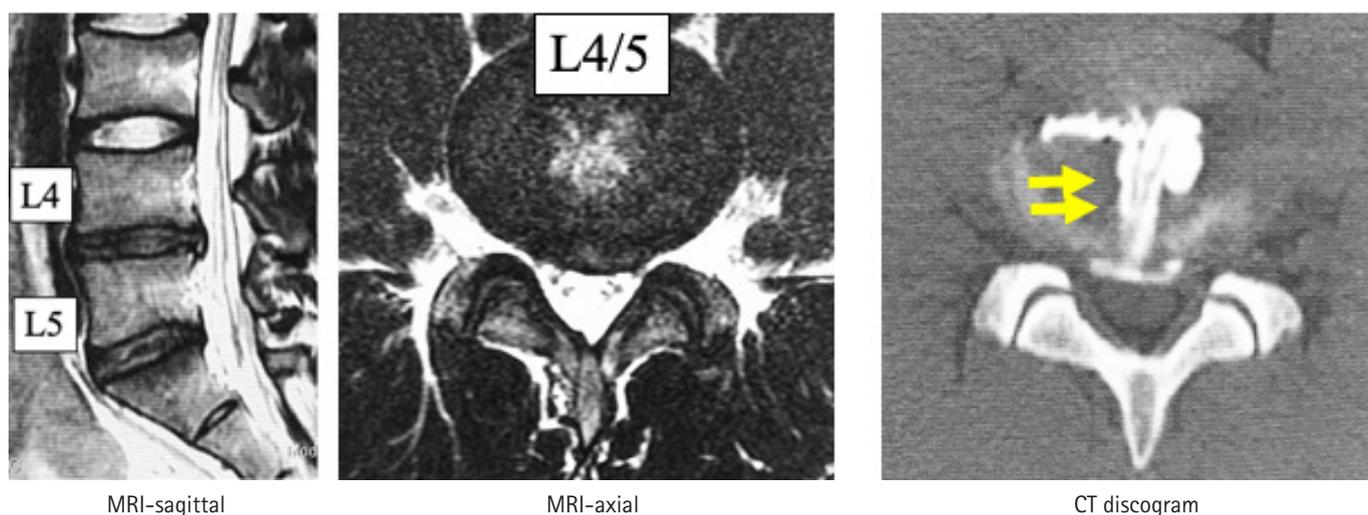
Findings on MRI and CT discography before thermal annuloplasty in a male baseball player with a clinical diagnosis of chronic discogenic pain. MRI shows disc degeneration at L4/5 and L5/S1. A slight high-intensity zone can be seen at L4/5 and a toxic annular tear is evident in the same level (arrows).
